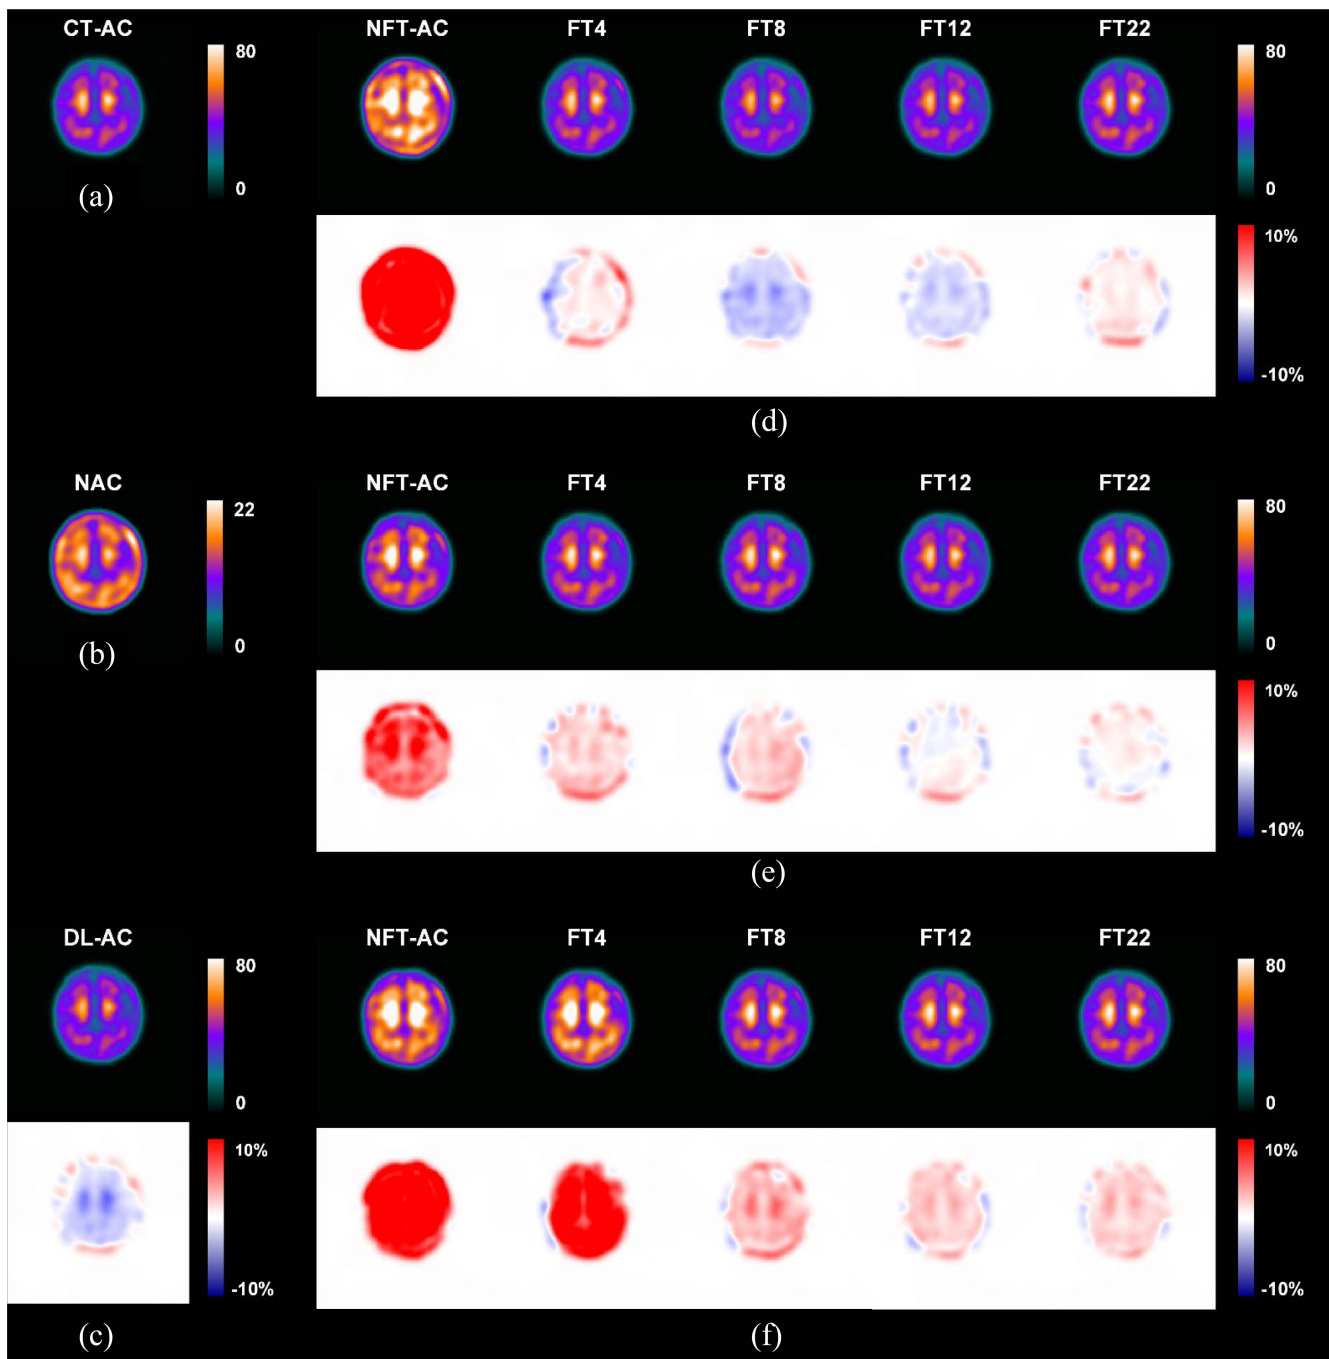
Representative results of an 81-year-old male patient. Sample axial SPECT images of (a) CT-AC, (b) NAC, (c) DL-AC, NFT-AC, and FT-AC methods with different numbers of FT data for the tested S-TRODAT-1 data using (d) S-ECD (cross-tracer), (e) G-TRODAT-1 (cross-scanner), and (f) G-ECD (cross-tracer+cross-scanner) as the pretrained network. The corresponding error map as compared to CT-AC is shown under each SPECT image, respectively.
